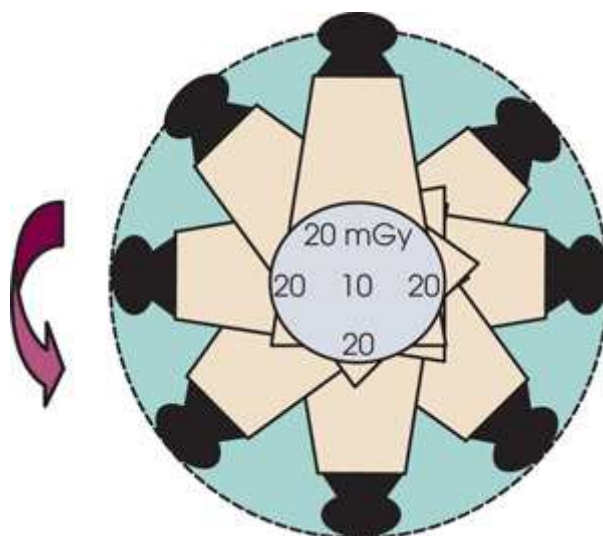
CT dose profile for body. Data from McNitt-Gray MF: AAPM/RSNA physics tutorial for residents: topics in CT. Radiation dose in CT. *RadioGraphics* 22:1541, 2002.
